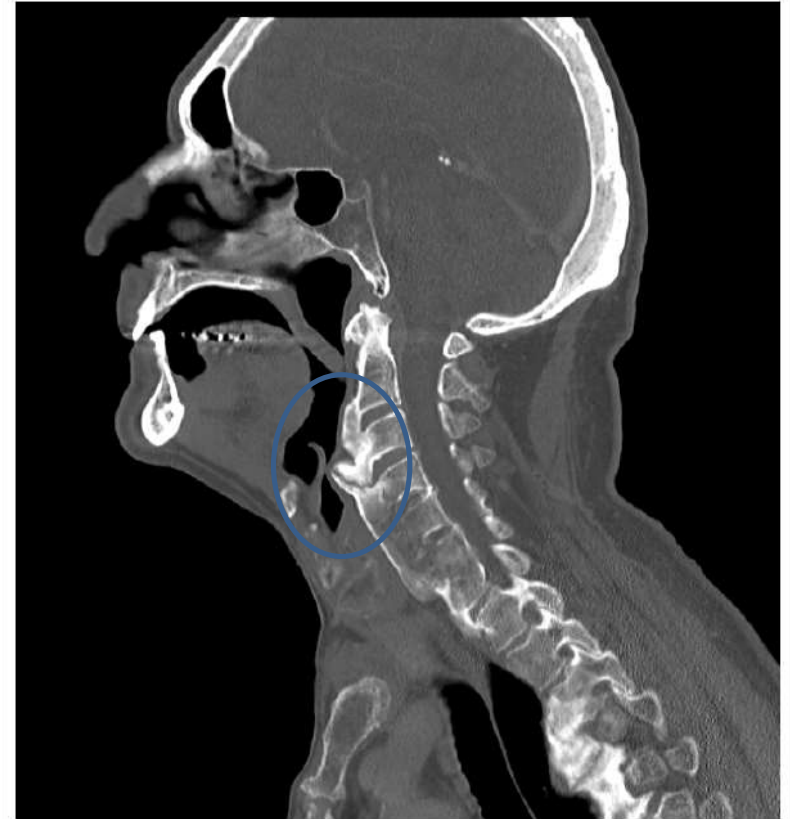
CT: sagittal scan showing anterior osteophytes and ossification of the anterior longitudinal ligament.
